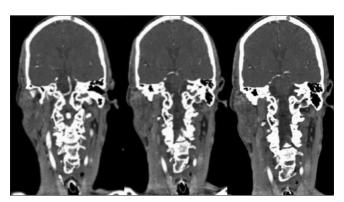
Follow-up CTA demonstrating patency of the basilar artery, the right-sided dominance of the vertebral artery, and patency of both posterior cerebral arteries
